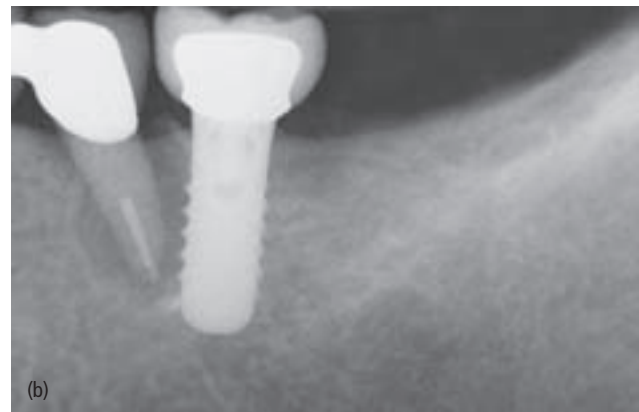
Misleading radiograph endangering an implant. (a) Initial radiograph of what appears to be an implant overlapping a tooth at site 20. (b) Corrected angulation of radiograph indicates that the tooth and implant do not touch. (c) Infected tooth 20 was removed. (d) Three months postoperative healing. The defect adjacent to the implant has resolved.
